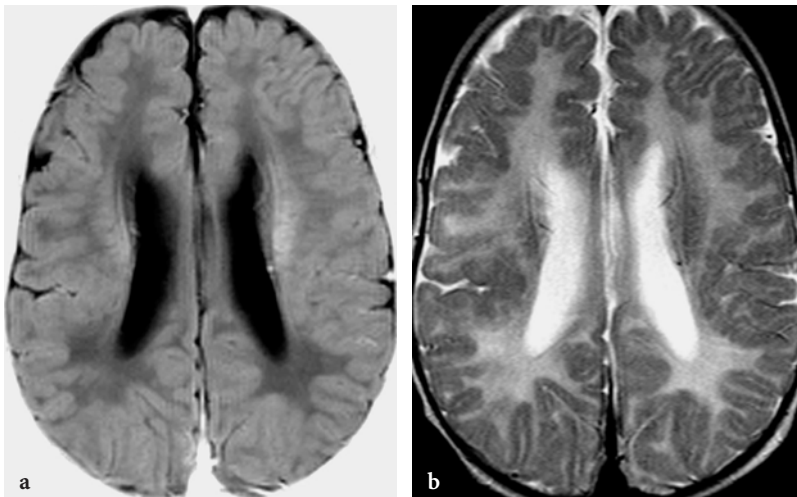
Cortical gyral abnormalities (polymicrogyria) in a 5-month-old female patient with Zellweger disease. a Axial T1-weighted fast inversion recovery image. The bilateral polymicrogyria-like cortical abnormalities around the Sylvian fissures are hardly visible. b Axial T2-weighted fast spin-echo image. The cortical abnormalities are easier to detect on this image because of the better gray-white matter contrast resolution on the T2-weighted images at this age
